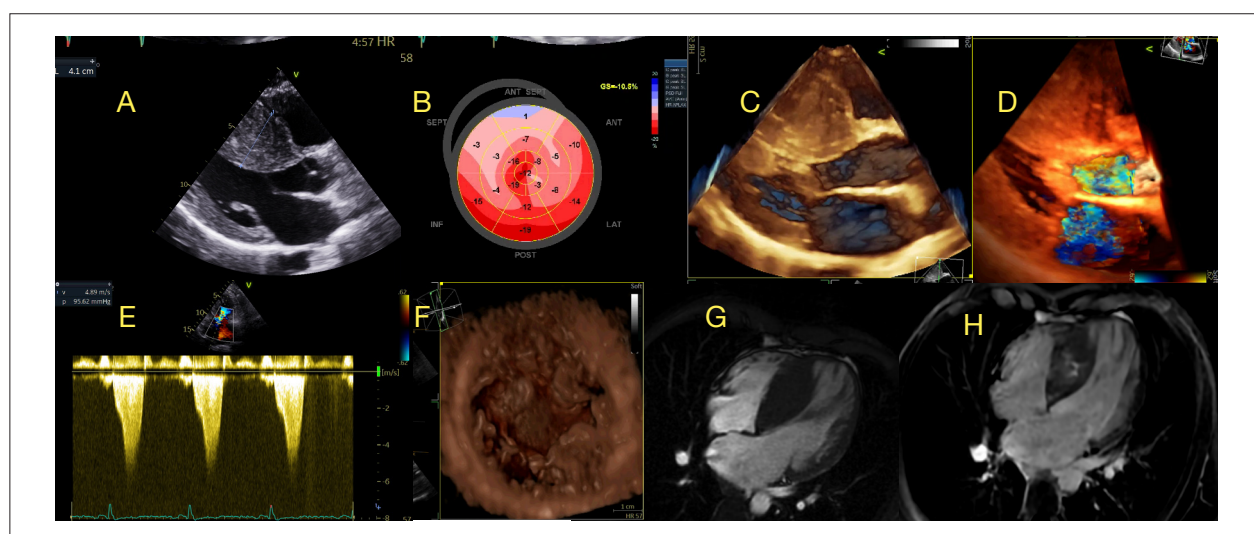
Example of a patient with obstructive Hypertrophic Cardiomyopathy. A) septal thickness: 4,1cm, B) Longitudinal strain pattern (bull's-eye) showing regional alteration mainly in septal and segments, C) 3D transthoracic echo (TTE) acquisition, rendered 3D images longitudinal showing systolic anterior motion (SAM) of the mitral valve in systole (*), D) 3D TTE acquisition, rendered color 3D images (longitudinal view) showing mitral regurgitation secondary to SAM (*), E) Continuous Doppler showing late peak rest gradient in left ventricular outflow tract of 96mmHg, classic dagger shape pattern, F) 3D TTE acquisition, rendered 3D images (short axis view) showing papillary muscles anomaly with 4 heads (*) and anteriorly positioned, G) Cardiac MR showing massive septal hypertrophy, and in H- late gadolinium enhanced images showing septal fibrosis with midwall pattern.
